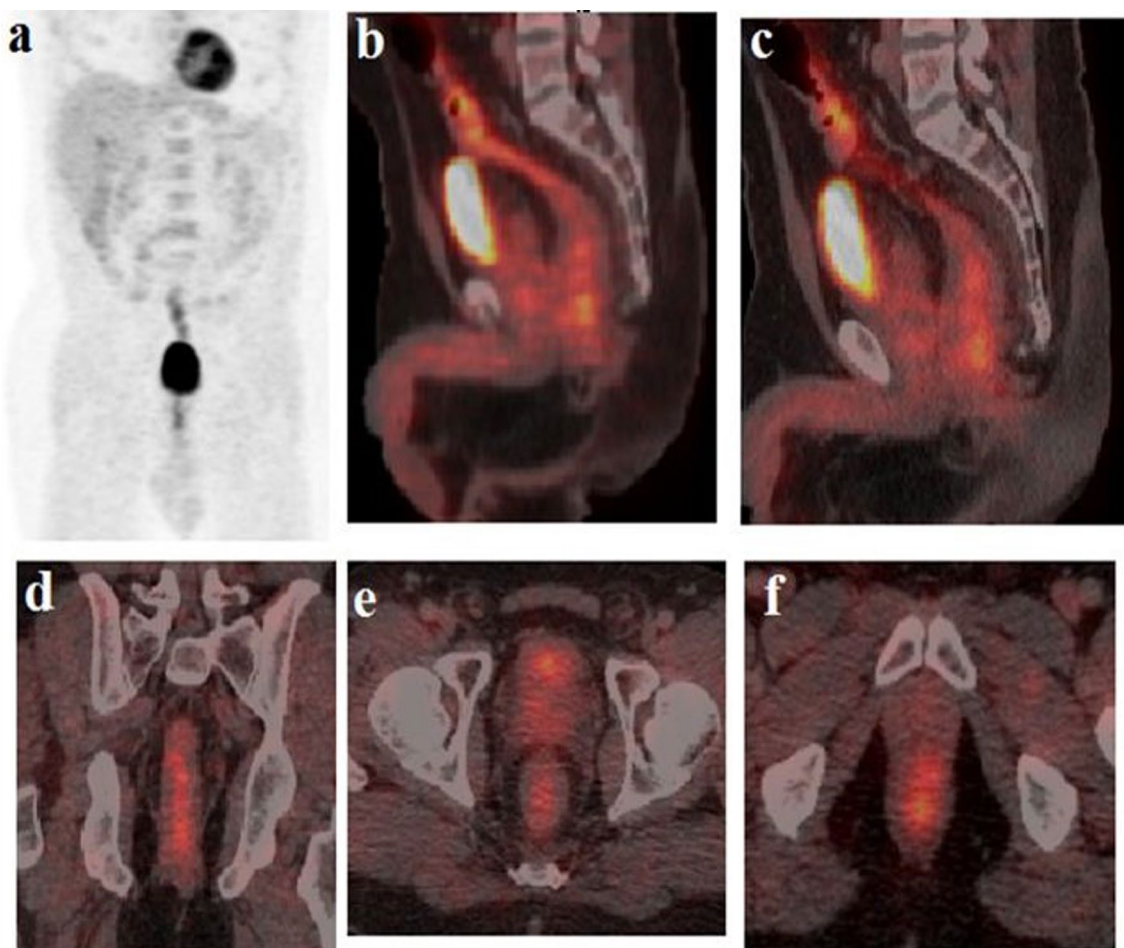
a–f PET/CT study for the same patient in Fig. 1. a MIP, b–f sagittal, coronal and axial Fused PET-CT images revealed: Long segment of diffuse central low grade FDG uptake seen involving the rectum and anal canal (max. SUV~4) (likely post therapeutic sequelae); however a focal eccentric area of slightly higher FDG uptake ((max. SUV~5) is seen involving the lower rectum at 6–7 O'clock (worrisome about residual viable tumoral lesions), for close follow-up
